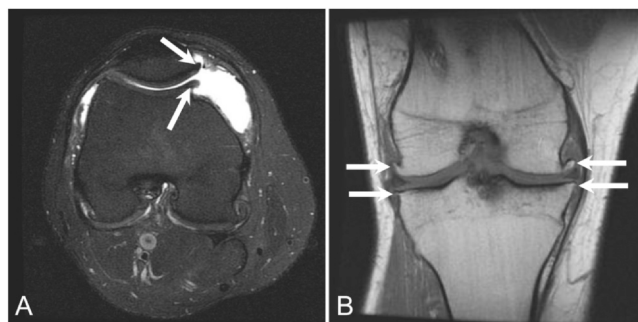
Professional football defensive lineman without acute injury presents for evaluation of right knee pain. Axial T2 FS (A) and coronal T1 (B) MR images demonstrate tricompartamental knee joint osteoarthritis with associated marginal osteophyte formation (arrows in A and B). FS, fat saturation; MR, magnetic resonance.
